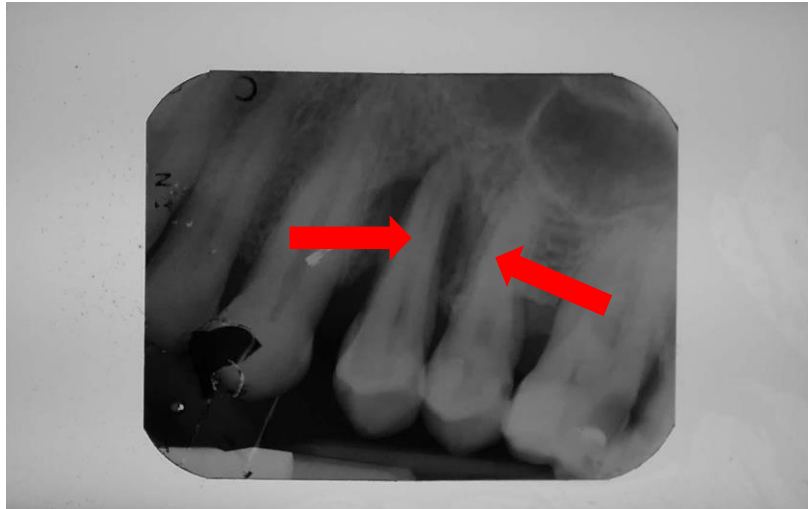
Diagnostic evaluation radiograph at patient recruitment with periodontal compromise in tooth 24 (arrows).
